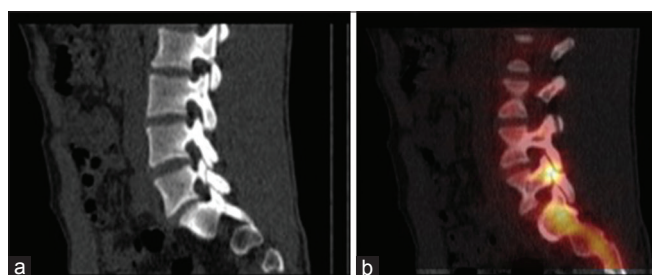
Sagittal low-dose computed tomography (a) and fused sagittal single-photon emission computed tomography-computed tomography (b) images showing moderate to intense ^{99m}Tc -methylene diphosphonate uptake localized to an oblique lucency traversing the pars interarticularis of L5, in keeping with a fracture in a young athlete^[12]
